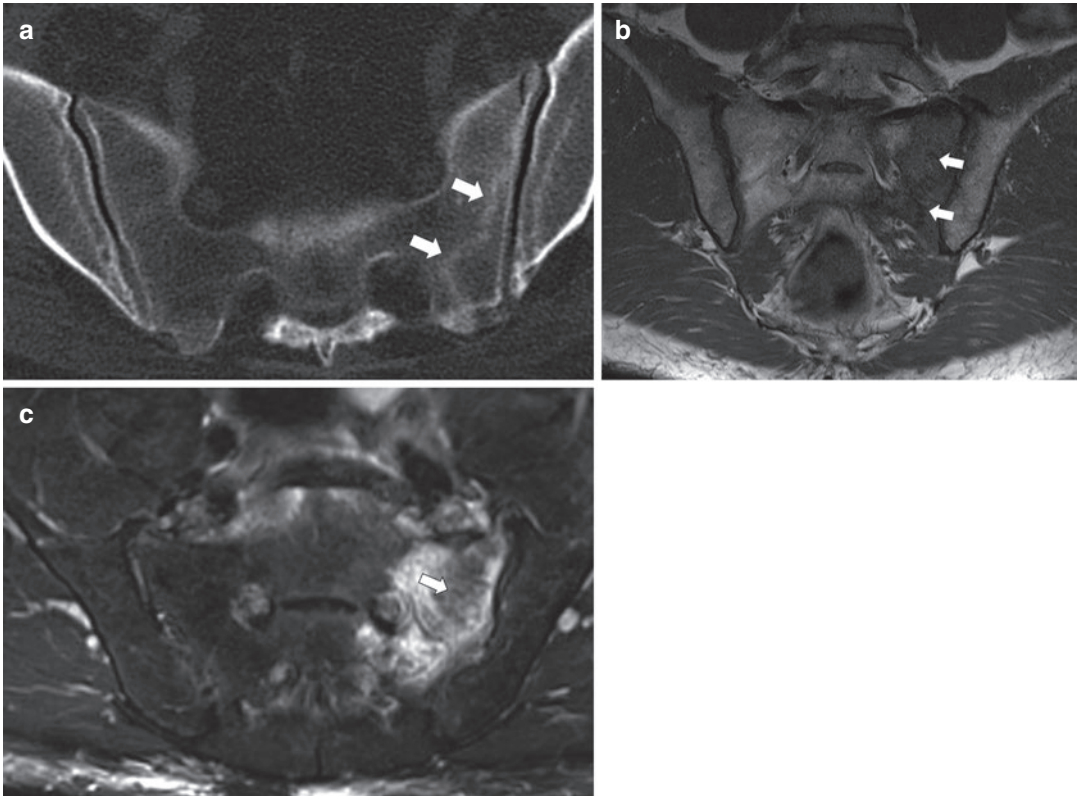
(a–c) Stress fracture of the sacrum in a 61-year-old woman with spinal arthrodesis (not shown). (a) Axial oblique CT scan image reveals linear hyperdensity on the left sacral wing (arrows), paralleling the sacroiliac joint space. Arthrodesis-related abnormal distribution of loads
